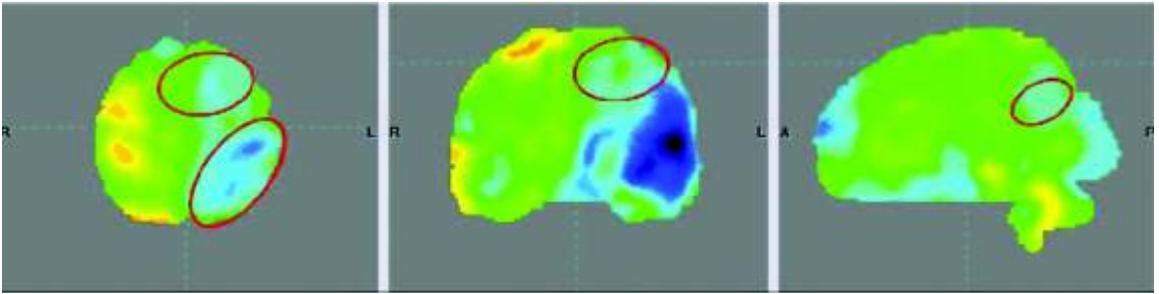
PET-CT scan after Autologous BMMNCs transplantation suggestive of increased metabolism in the regions of left frontal lobe, occipital lobe and basal ganglia
